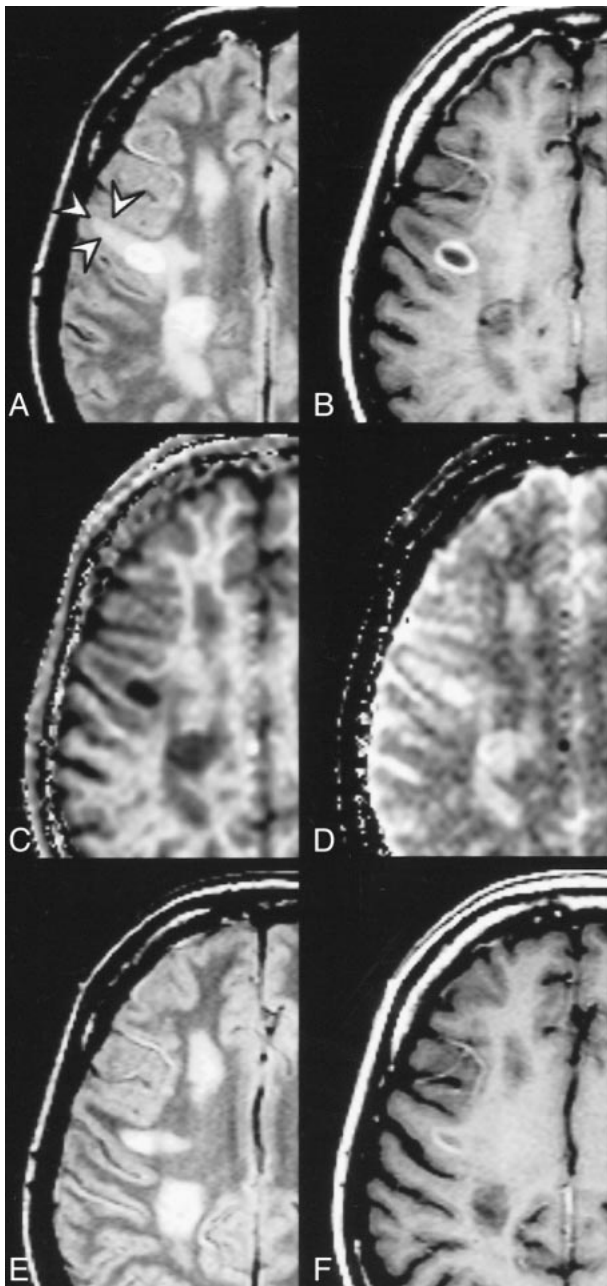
Ring-enhancing lesion surrounded by edema (arrows) and multiple non-active lesions. Proton density-weighted (2060/20/1) (A), postcontrast T1-weighted (510/14/2) (B), k_{for} (C), and $T1_{free}$ (D) images. The quantitative analysis in the acute lesions yielded the following results: ring-enhancing lesion: MTR = 16.4%, k_{for} = 0.13 s⁻¹, $T1_{free}$ = 1.5 s; edema: MTR = 41.1%, k_{for} = 0.56 s⁻¹, $T1_{free}$ = 1.2 s. Proton density-weighted (E) and postcontrast T1-weighted (F) images acquired 6 weeks later. Disappearance of perifocal signal abnormality supports the assumption of edema.
